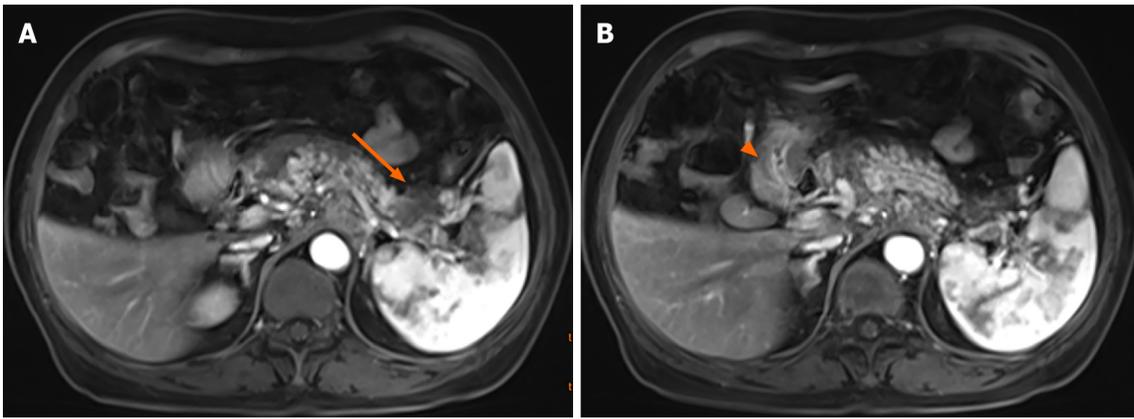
Enhanced upper abdominal magnetic resonance imaging. A: An intensified mass (orange arrow); B: Thickening of the pyloric wall (orange arrowhead).
